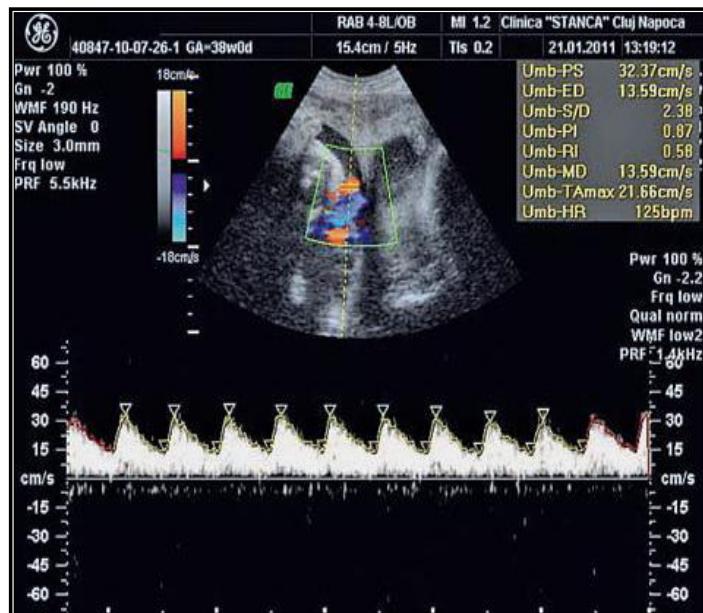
UA Color Doppler and Normal Pulsed I
